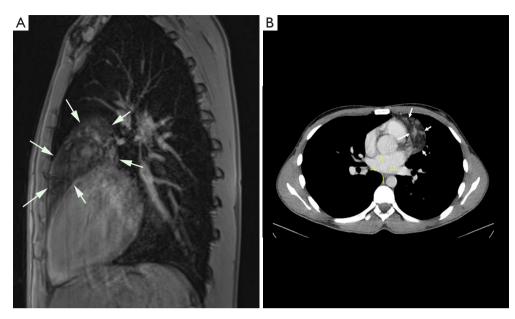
MRI and CT-scan. (A) Post-contrast T1 vibe (volumetric interpolated breath-hold examination) fat saturated sagittal MR-image, depicting a supra-cardial fatty mass (indicated by arrows). (B) Contrast-enhanced transverse CT-image showing the left para-cardial located low density mass (indicated by arrows). MRI, magnetic resonance imaging; CT, computed tomography; MR, magnetic resonance.
